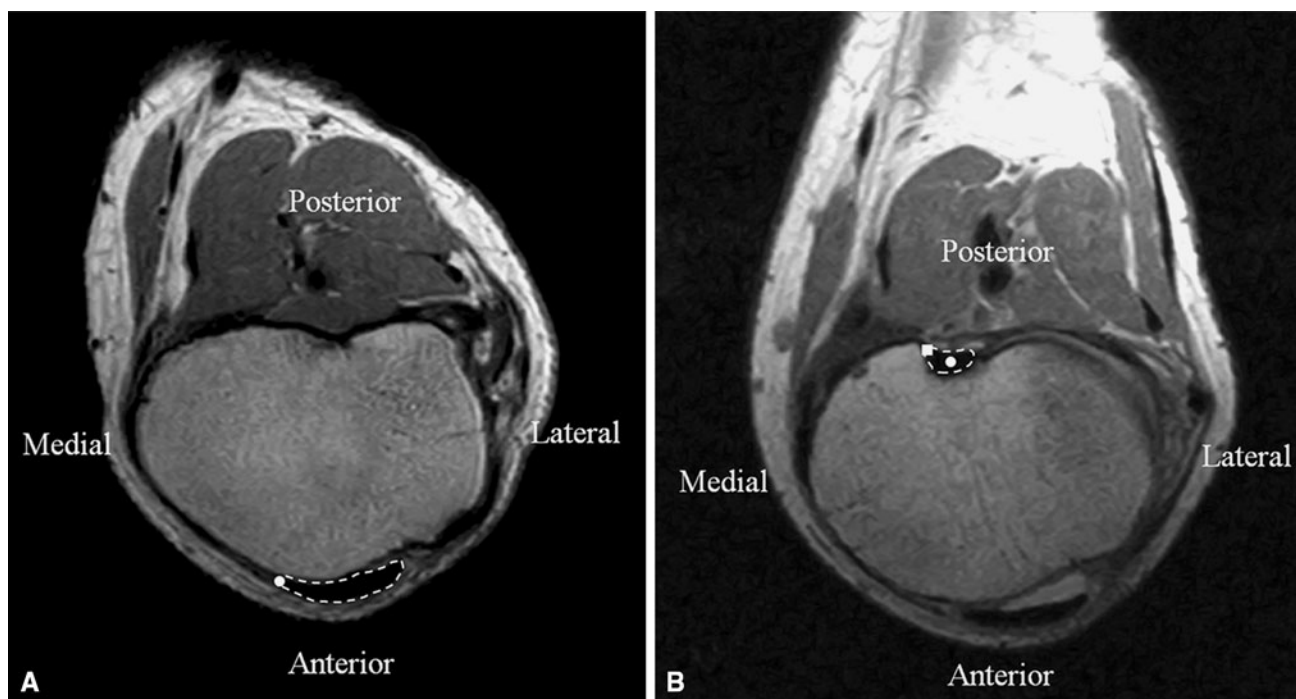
MR images show (A) the medial border of the patellar tendon at the tibial attachment level (white circle) and (B) the middle (white circle) and medial borders (white rectangle) of the PCL at the tibial attachment.
